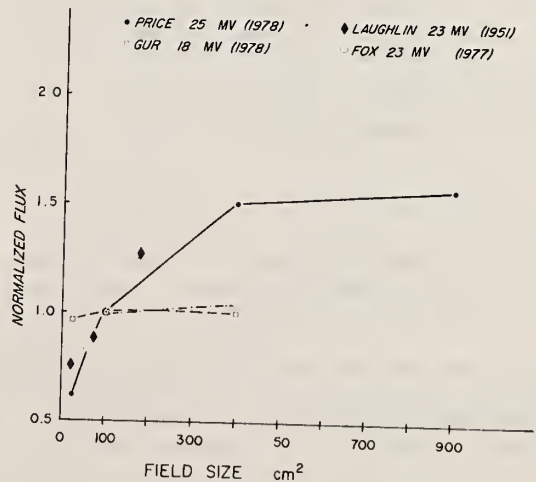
Fast neutron fluence in x-ray beam as a function of field size. Normalized at 100 cm<sup>2</sup>.
